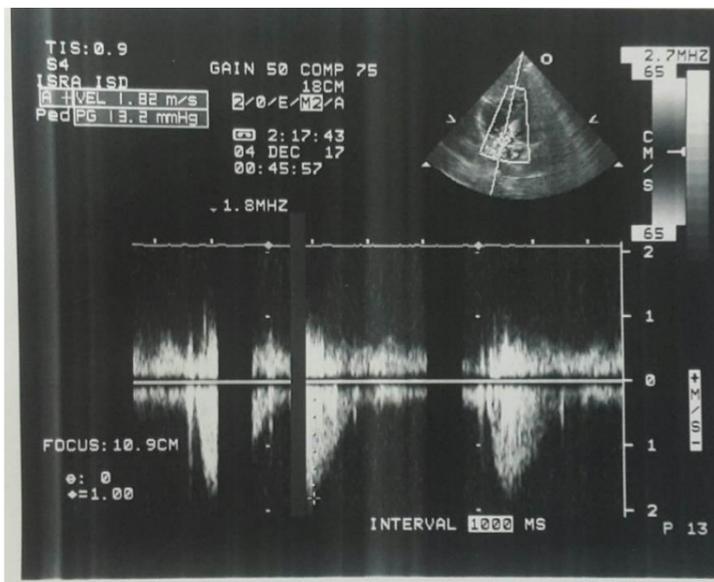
Echocardiography report showing aortic stenosis
